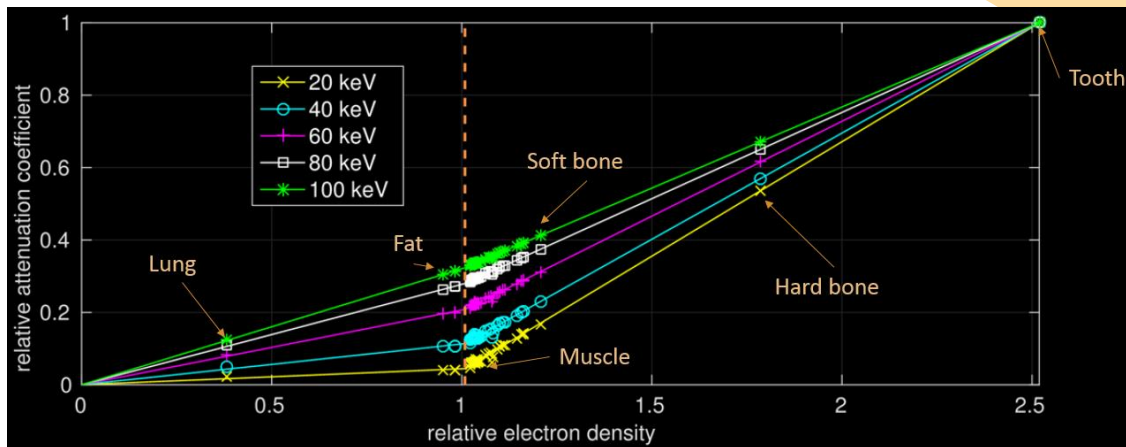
Nonlinear X-ray attenuation against electron density for human tissues according to [2], where each colour represents various photon energies. A piecewise linear fit has been superimposed with a consistent transition point.
